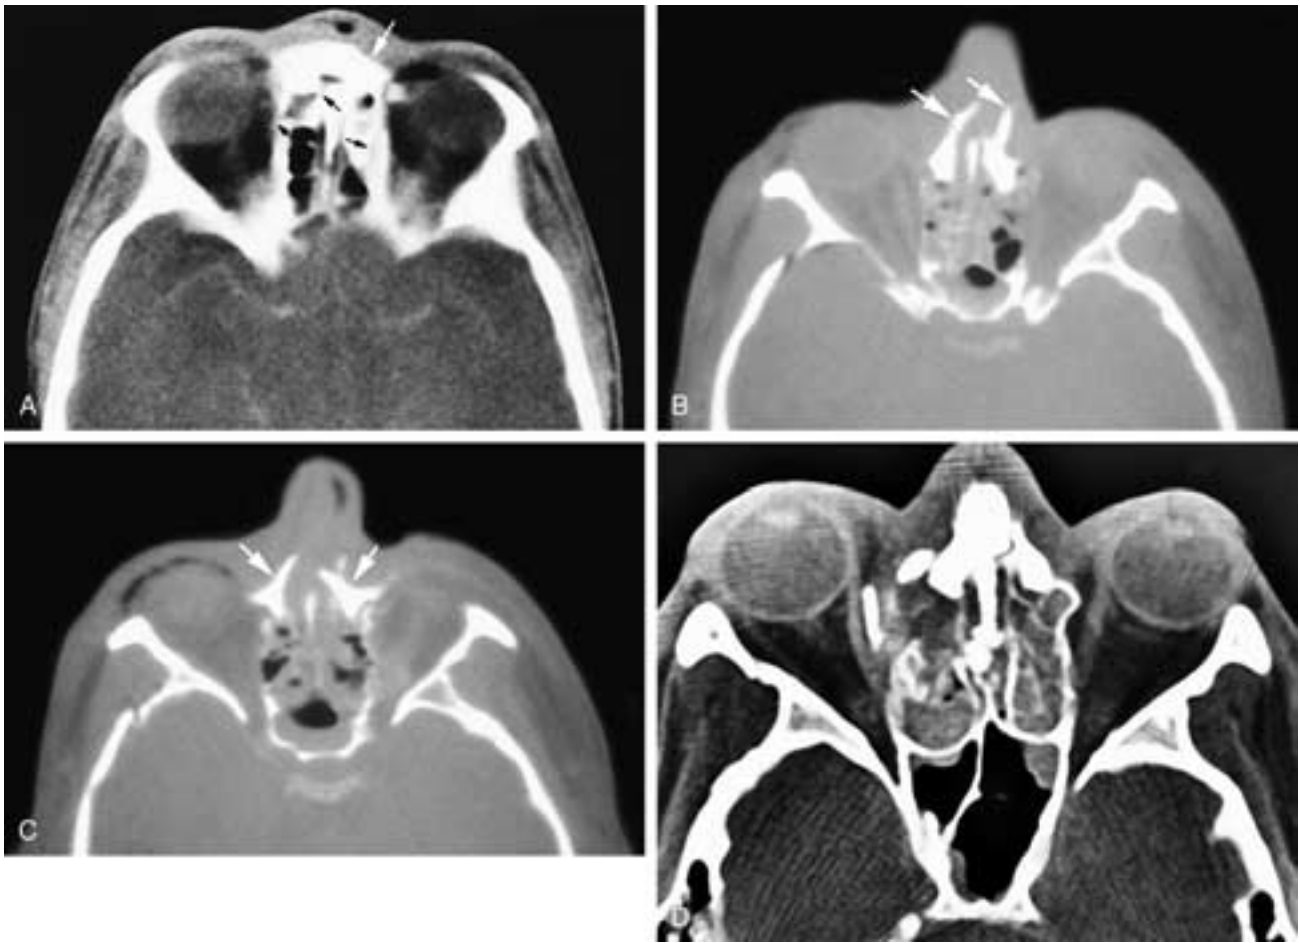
Axial CT scan (A) shows a nasoorbital fracture with posterior displacement of the region of the nasion (*white arrow*) and fractures through the fovea ethmoidalis (*small arrows*). Axial CT scan (B) shows a nasoorbital fracture with posterior displacement and rotation to the left side of both nasal bones and the frontal processes of each maxilla (*arrows*). There are also fractures of the ethmoids with some hypertelorism. Axial CT scan (C) shows a nasoorbital fracture with posterior and medial displacement of both nasal bones and each frontal process of the maxilla. There are also multiple fractures of the ethmoid complex and some hypertelorism. Axial CT scan (D) shows a nasoorbital fracture with posterior displacement of the nasal bones and fractures and hypertelorism of the ethmoid complex.
